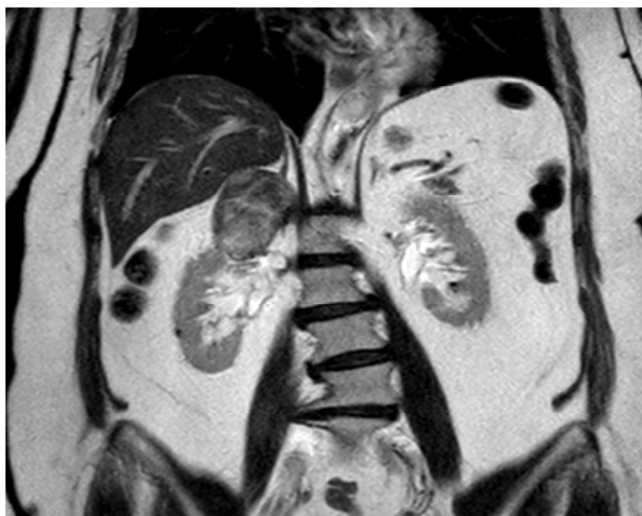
MRI showing size and relations of BIBC adrenal metastases.
